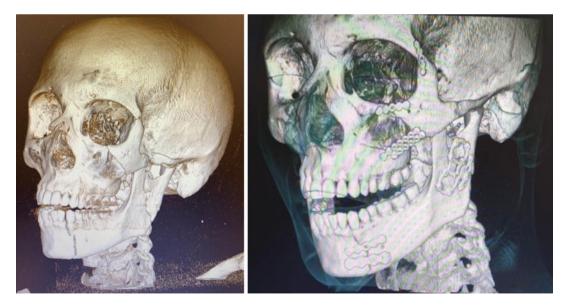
CT scan in a 3D reconstruction showing preoperative and postoperative multiple mandibular fracture of the left parasymphysis, left ramus, left O.M.Z.C. treated with internal fixation
